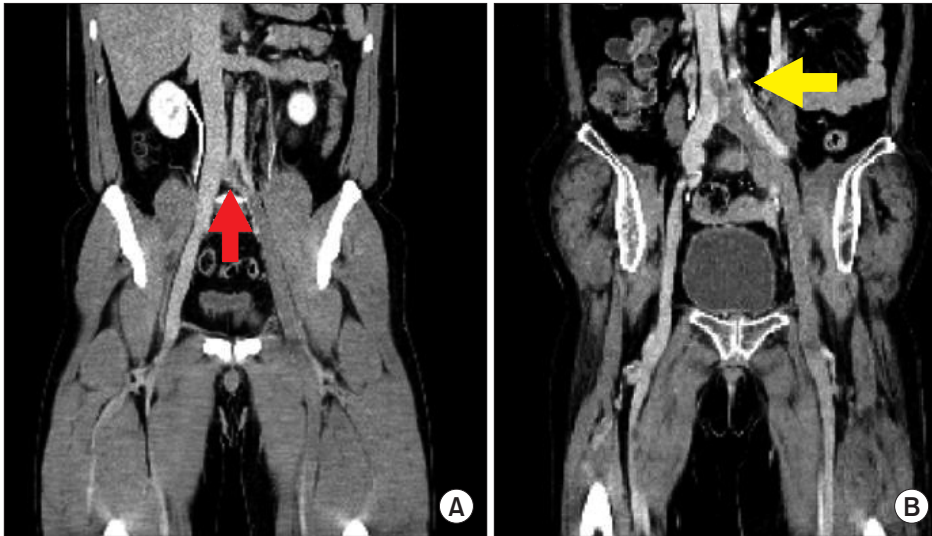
Coronal view on a computed tomography scan of a patient with May-Thurner syndrome. (A) Stenotic lesion in the left common iliac vein (arrow) without thrombosis beyond iliac vein stenosis (TBIVS). (B) Stenotic lesion in the left common iliac vein with TBIVS (arrow).
